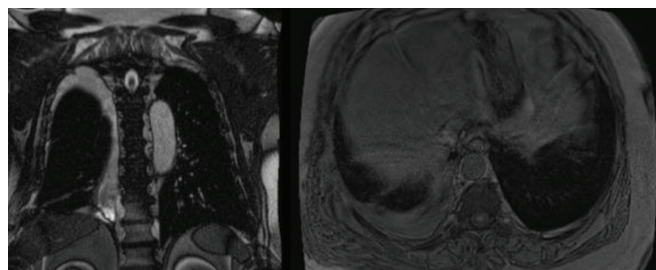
Thoracic magnetic resonance imaging revealing a 9x1 cm intercostal defect.
